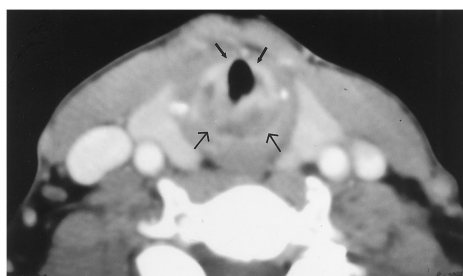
Radiation chondritis. Axial enhanced CT image of a patient who had received radiation therapy for a squamous cell carcinoma of the hypopharynx shows the posterior portion of the cricoid cartilage to be thicker and of lower density (*large arrows*) than the more normal anterior portion (*small arrows*).
